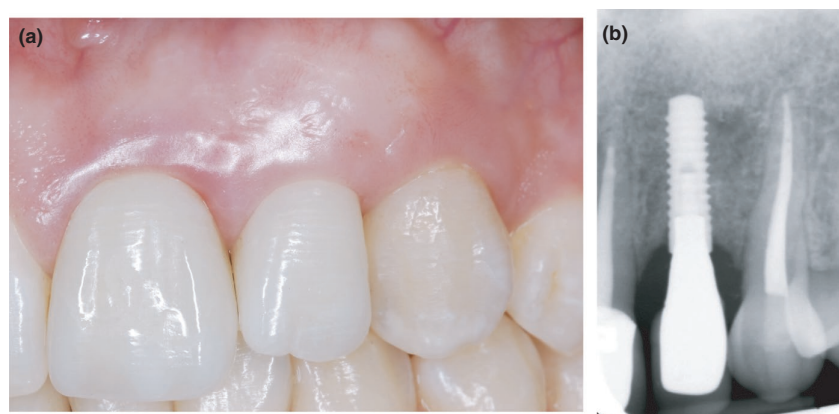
(a) Follow-up after 10 years of supportive periodontal therapy; (b) final X-ray evaluation
